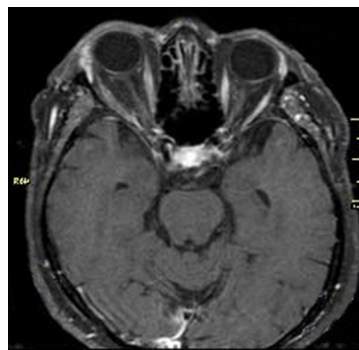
Orbital MRI of the patient on the first presentation.
